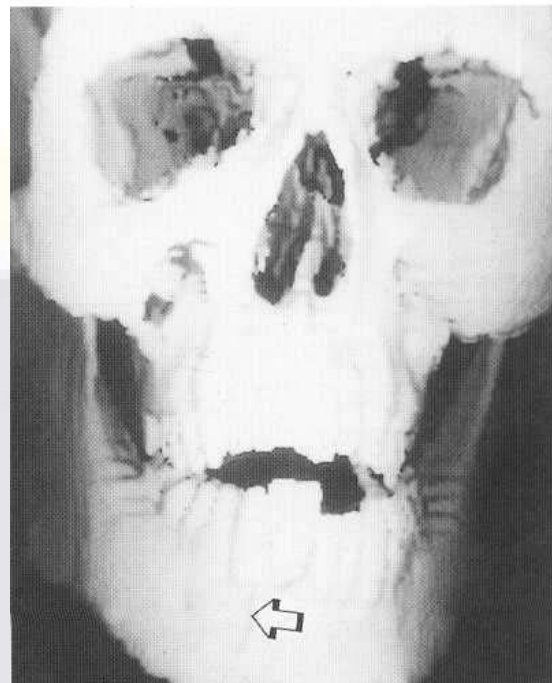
Mandibular fracture (arrow): 3D CT. Fine detail is provided by the 3D reconstruction.
